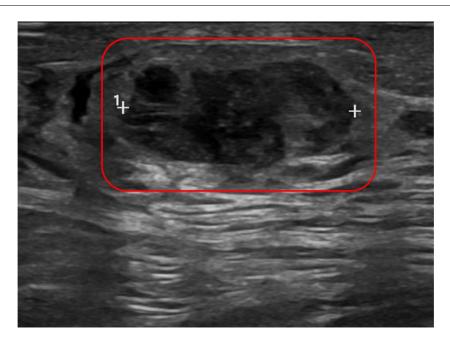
Left breast ultrasound demonstrating a lobulated, wider-than-tall, hypoechoic mass reflecting a recurrent lesion (red box).
